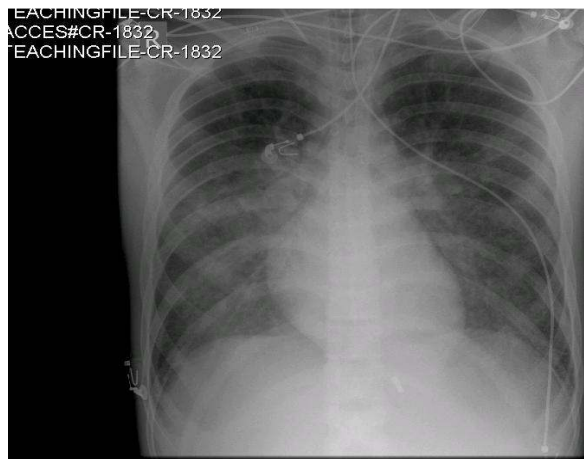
3 (CR-1832): In this radiograph, the right sided IJV cannula is too high in the neck. This will not give an accurate CVP measurement. Besides, there is also a risk that the CVC might get dislodged and lead to extravasation of administered fluids and drugs.
